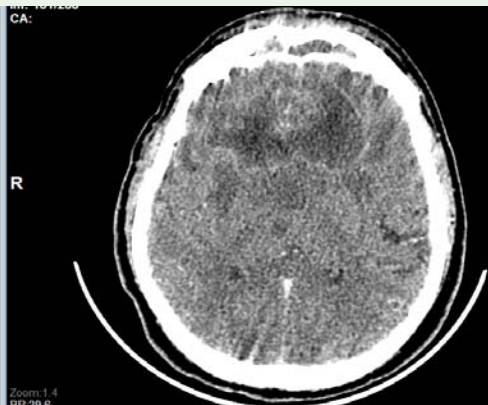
CT Scan Brain - bifrontal abscess.
